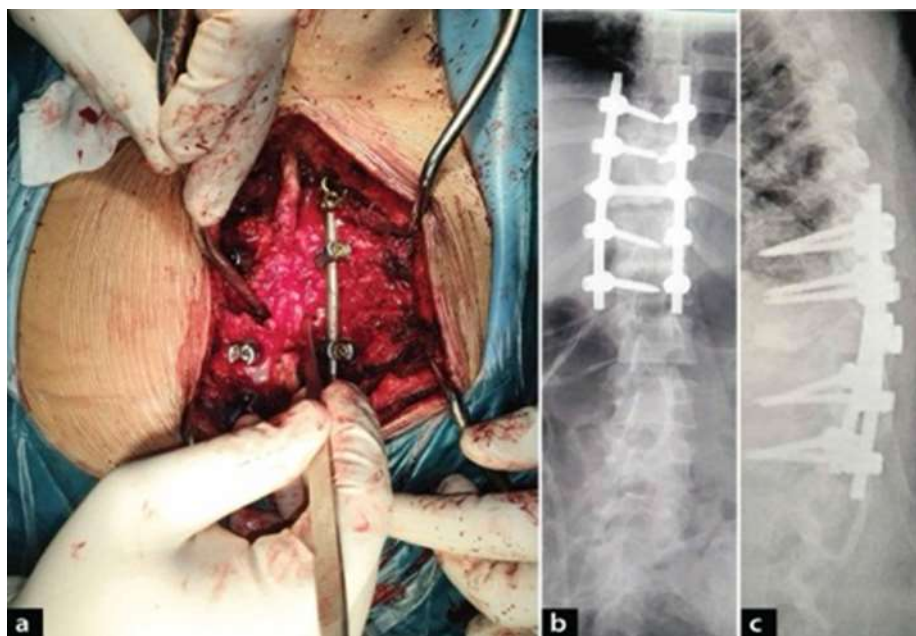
Intraoperative image (a) and immediate postoperative plain radiograph (b and c). Posterior fusion of T9-L2 is shown in (b) anterior-posterior and (c) lateral projection.
